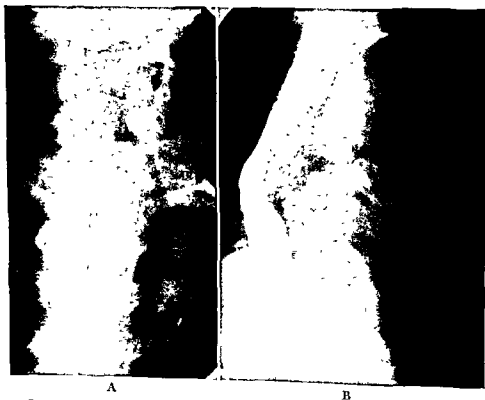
Roentgenogram showing displacement of (A) trachea and (B) esophagus by goiter at thoracic inlet.
